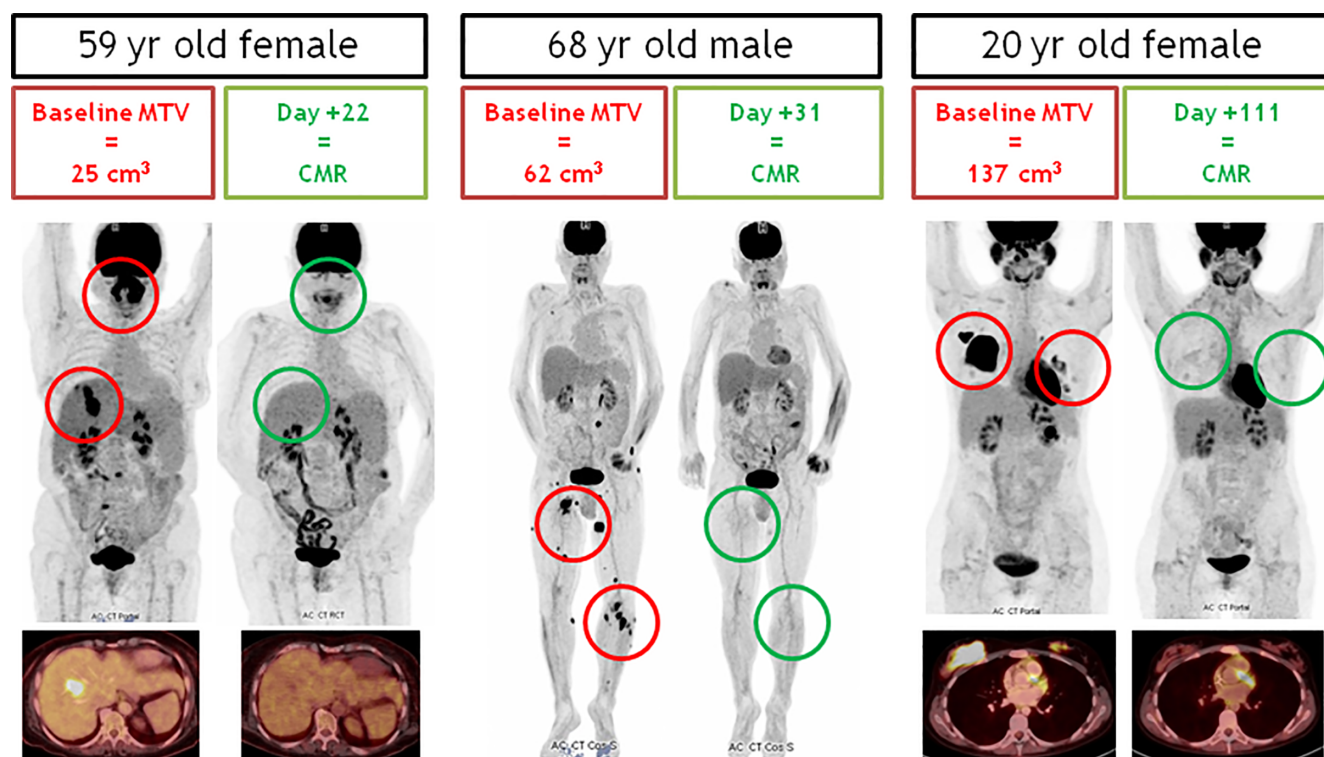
PET-CT scans of three different patients before and after ARI-0001 cell therapy. Post-therapy scans are those where the first complete metabolic response was documented, whenever that happened. Red circles highlight the most representative locations of abnormal [^{18}F] fluorodeoxyglucose uptake before therapy, while green circles highlight the same locations after therapy. MTV, metabolic tumor volume; CMR, complete metabolic response [Color figure can be viewed at wileyonlinelibrary.com]
